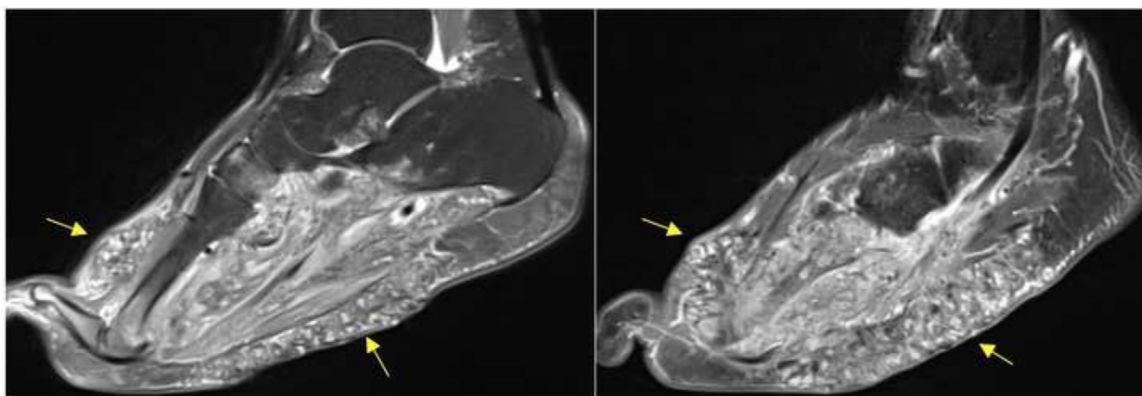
Case 2. Sagittal MRI sections in data proton weighting (A) and fat-suppressed T1 weighting after gadolinium injection (B), showing the previously described mycetoma grains, with infiltration of the adjacent muscles, and intermuscular fascial planes. Some of them have the "dot in a circle".
